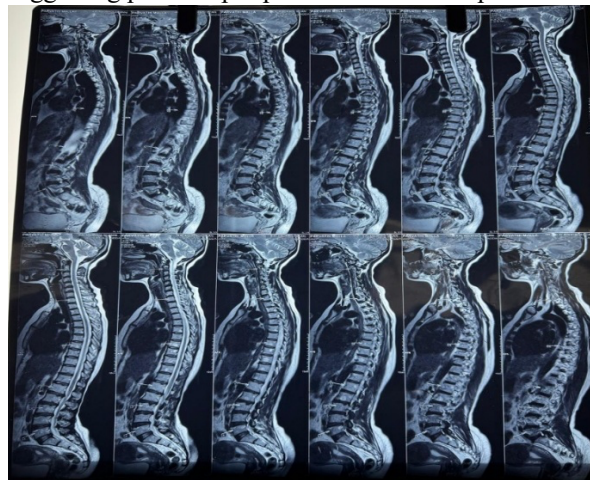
MRI Spine Showing Longitudinally Extensive Spinal Cord Lesion Suggestive of Transverse Myelitis (Lupus Myelitis)
